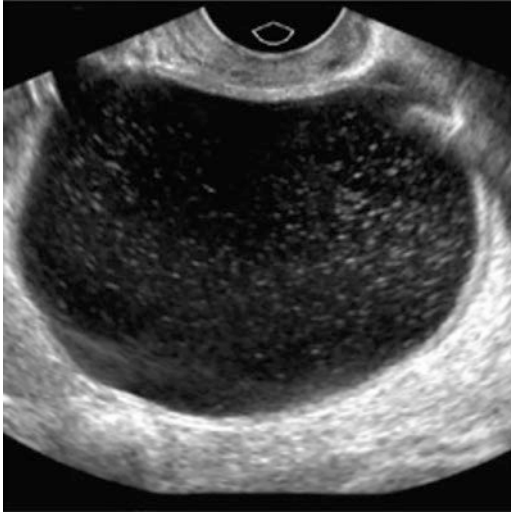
Findings suggestive of, but not classic for, hemorrhagic cyst, endometrioma, or dermoid. For premenopausal women, 6–12-week follow-up US is recommended to ensure resolution. If the lesion is unchanged, then hemorrhagic cyst is unlikely, and continued follow-up with either US or MRI should then be considered. If these studies do not confirm an endometrioma or dermoid, then surgical evaluation should be considered. For postmenopausal women, surgical evaluation should be considered
